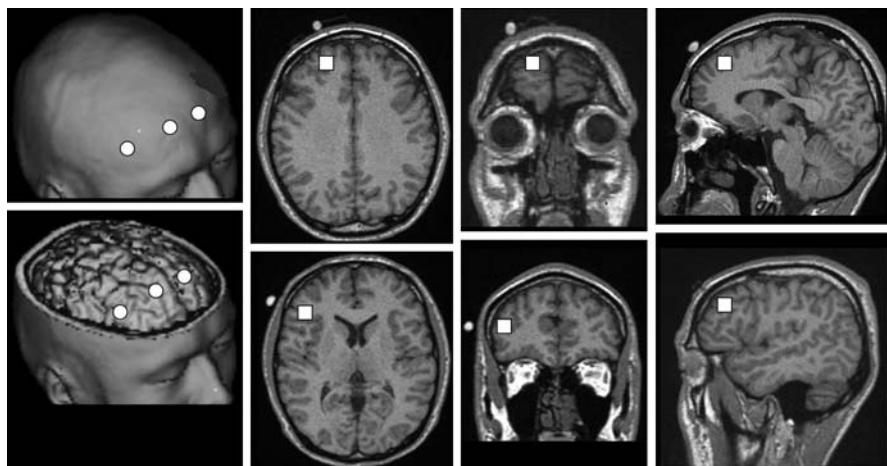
Estimation of the localized portions of NIRS by MRI. White circle; the center of probe. White square; the estimated region in the right frontal lobe detected by NIRS. High intensity on the scalp showed the Vitamine E capsules as the marker of the probes
